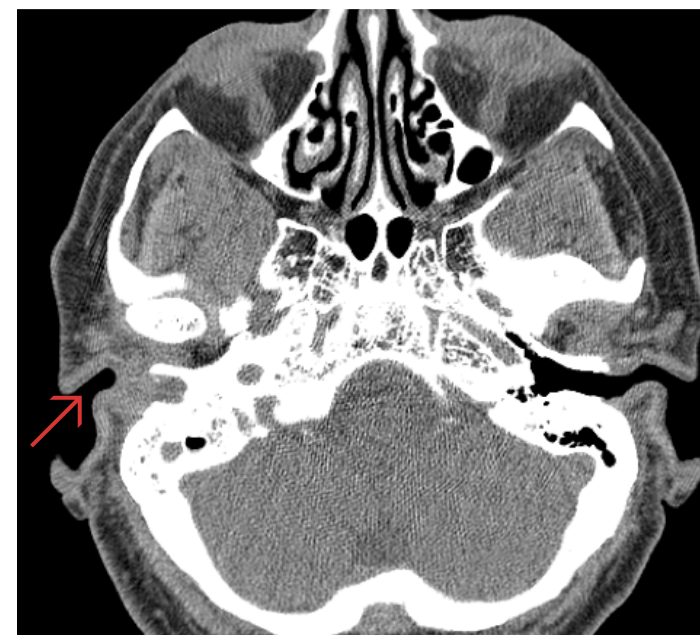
CT Orbit-Sella-IAC Impression: Occlusion of the external auditory canal of the right by soft tissue density. There is associated swelling of the cartilaginous portion of the external auditory canal. The process appears chronic with remodeling of the bony external auditory canal and minimal if any suspected erosive changes.
